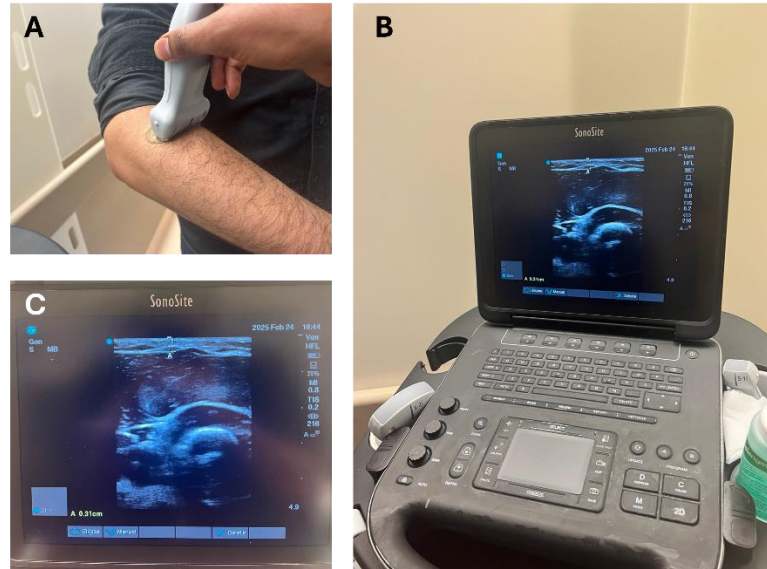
Ultrasound measurement of adipose tissue thickness over the brachioradialis muscle. (A) Ultrasound probe placement on the forearm. (B) Ultrasound device setup used for imaging. (C) Ultrasound measurement interface displaying adipose tissue thickness in millimeters.
